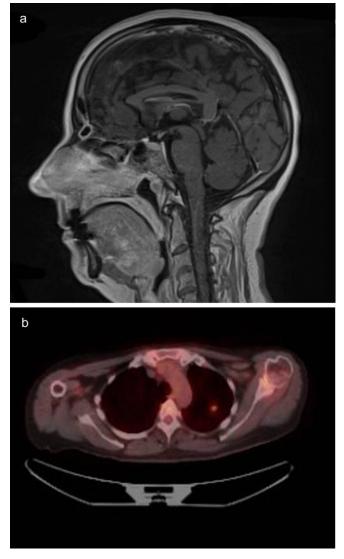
Initial findings. (a) MRT shows broad tumor infiltration of the midface. (b) PET/CT suggests metastasis in the left upper lobe of the lung
